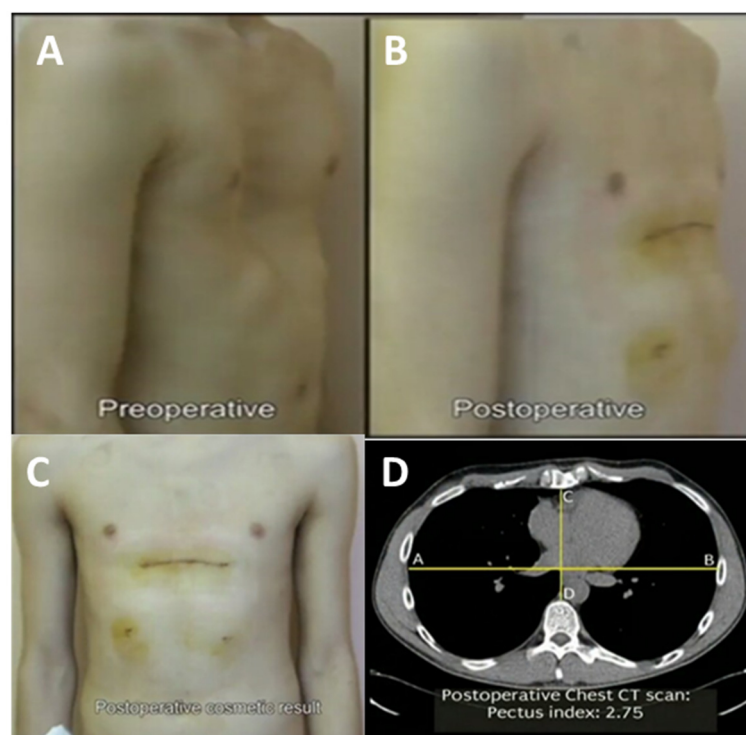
Postoperative pictures showing: A: comparison between Preoperative sternal deformity and B&C: postoperative results with a linear scar and good cosmetic result; D: Postoperative CT chest (Axial view) with HI 2.75.
